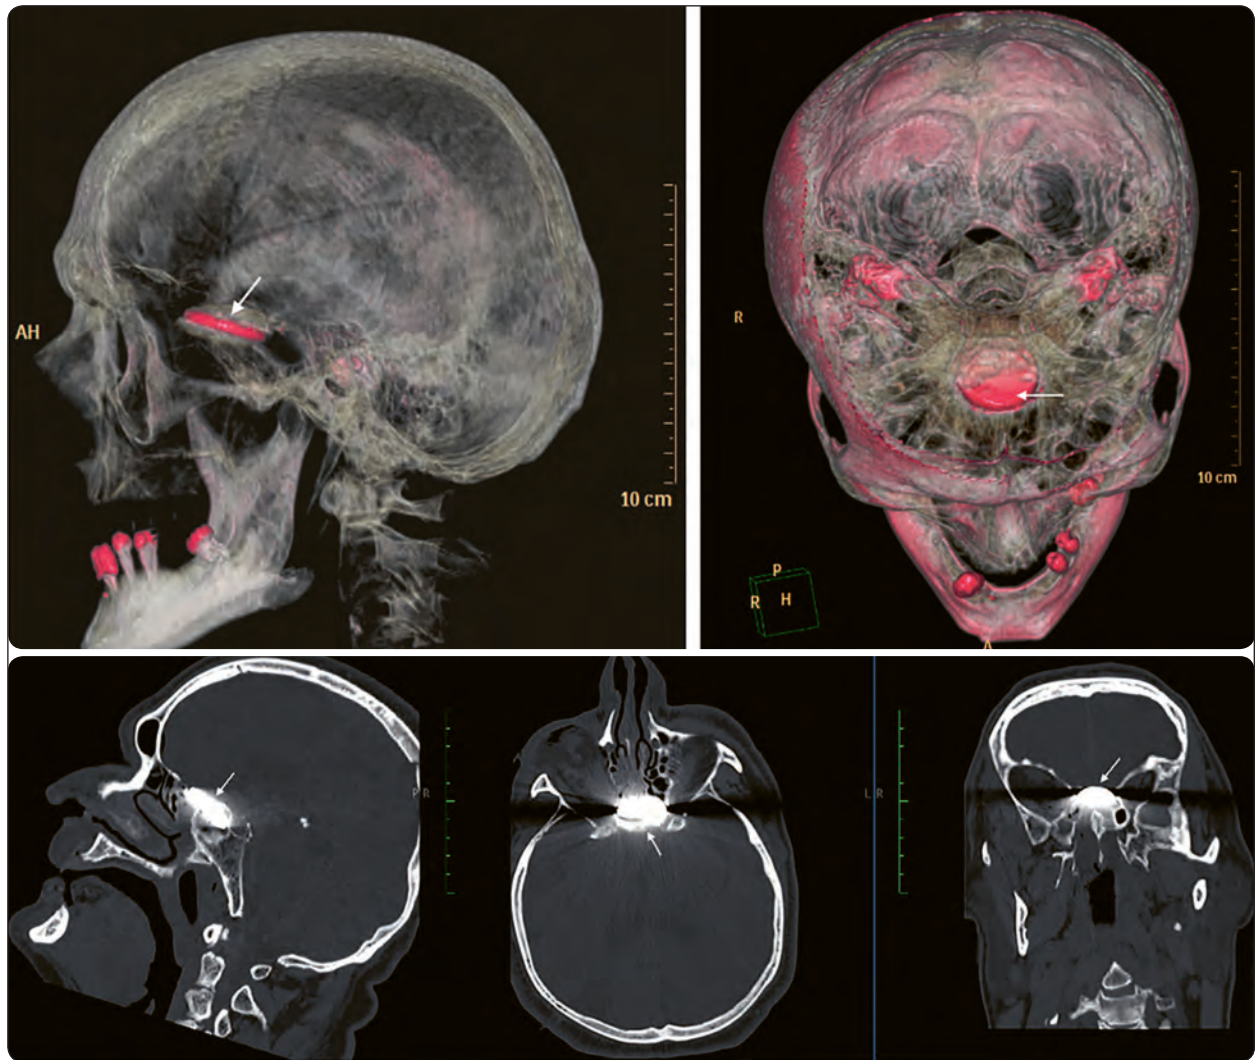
3D reconstruction of the axial CT scan, showing a coin-shaped foreign body (marked with arrow) in medial, frontobasal area above the planum sphenoidale extended into intracranial space. Three plane reconstruction (axial, coronal and sagittal) show a probably metallic foreign body (marked with arrow)
